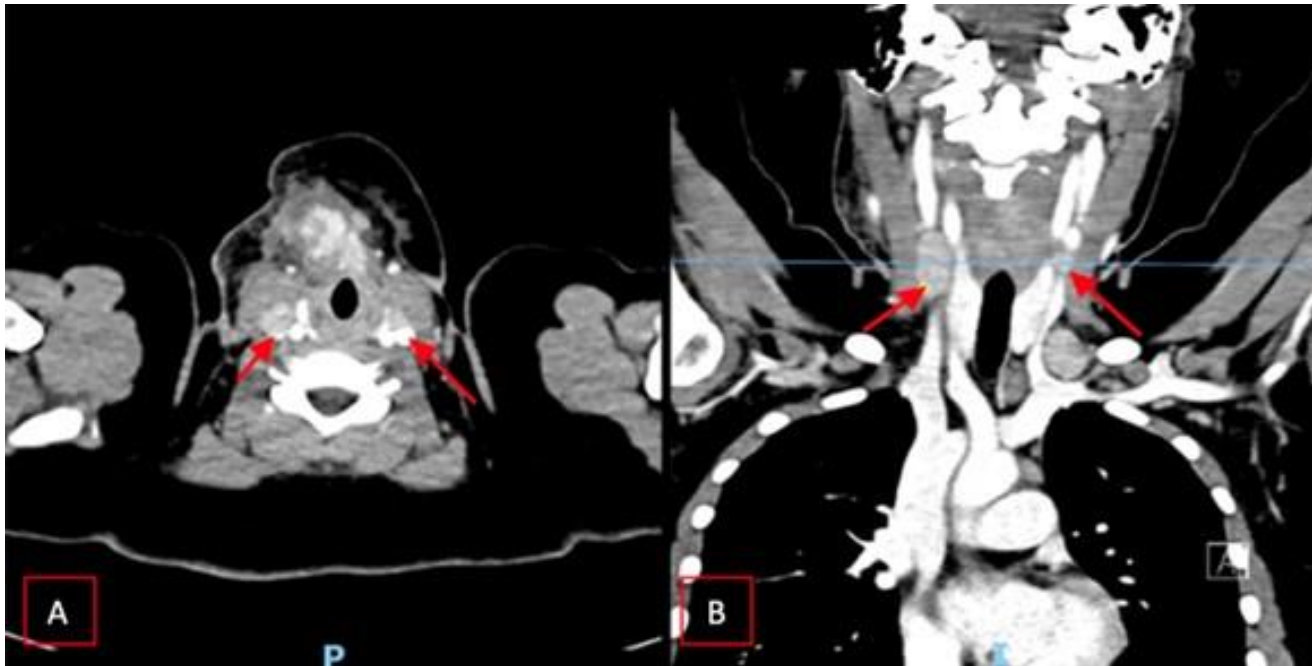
Computed tomography scans in axial (A) and sagittal (B) views demonstrate the complex lobulated solid cystic mass in the midline and the right internal jugular vein being compressed by cervical lymph node.
